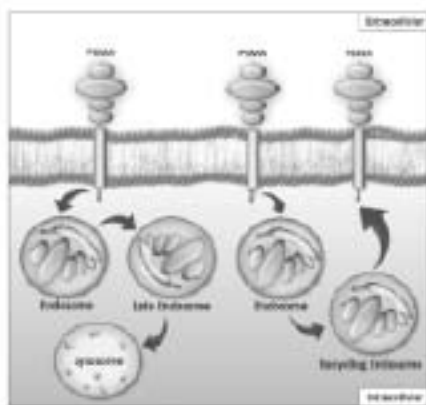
Spontaneous or antibody induced internalization of PSMA through clathrin coated pits. PSMA can either go to the lysosomes through late endosomes or be recycled by recycling endosomal compartment (REC). The internalization into endosomal vesicles is enabled by the cytoplasmic tail of PSMA, which contains an internalization signal.
